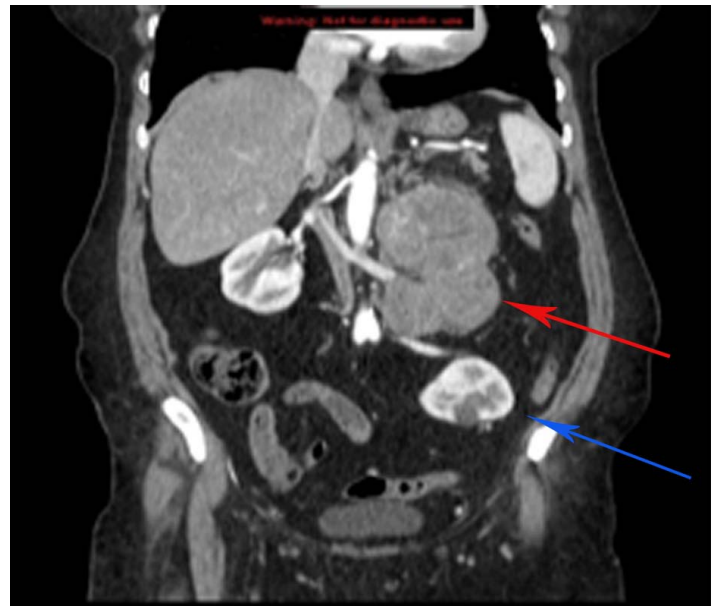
Coronal CT section showing the retroperitoneal mass displacing great vessels and taking direct blood supply from them (red arrow). See also the congenital, malrotated, left ectopic pelvic kidney (blue arrow).
